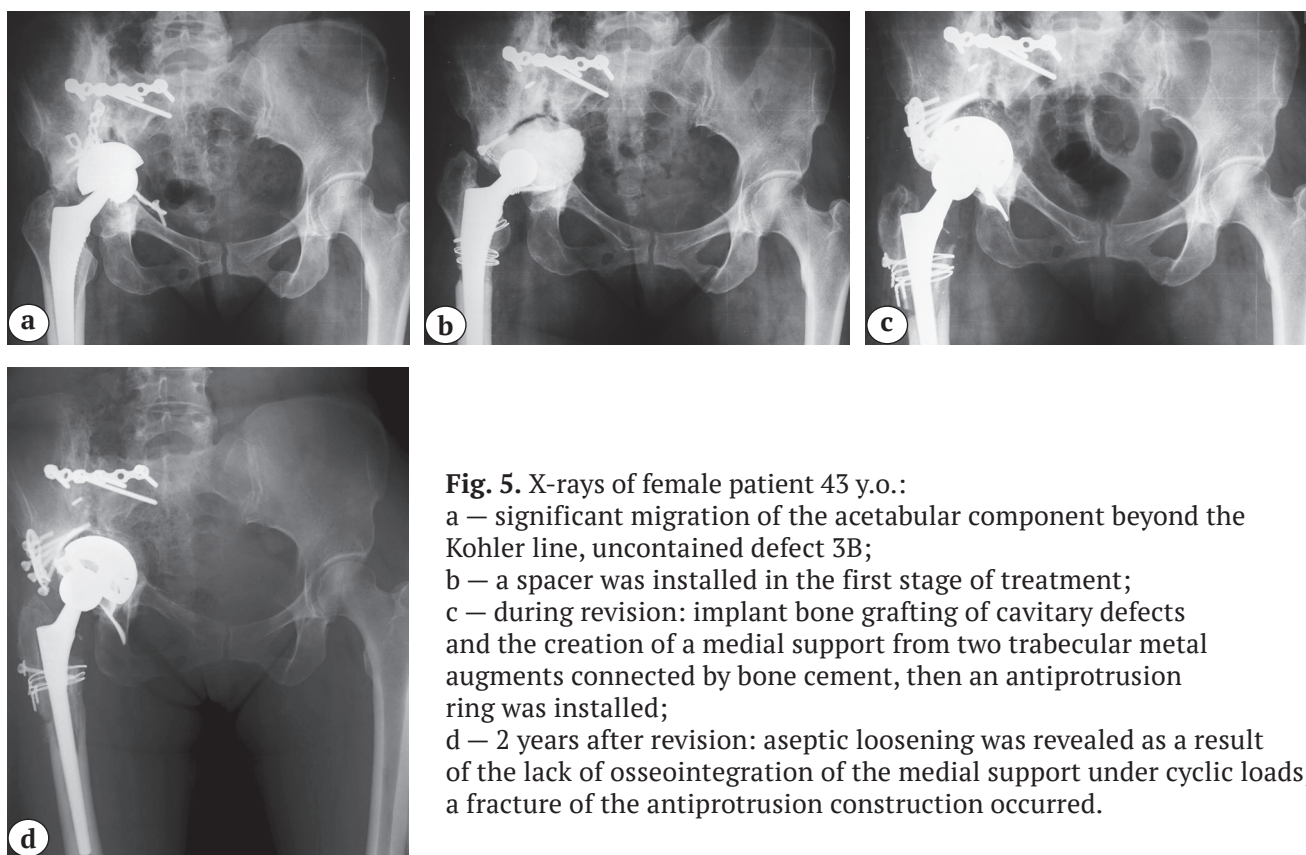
X-rays of female patient 43 y.o.:
